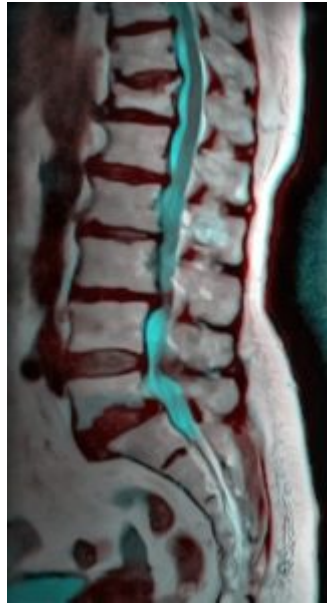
Lumbar MRI. By: Nevit Dilmen. License: [CC BY-SA 3.0](https://creativecommons.org/licenses/by-sa/3.0/)
